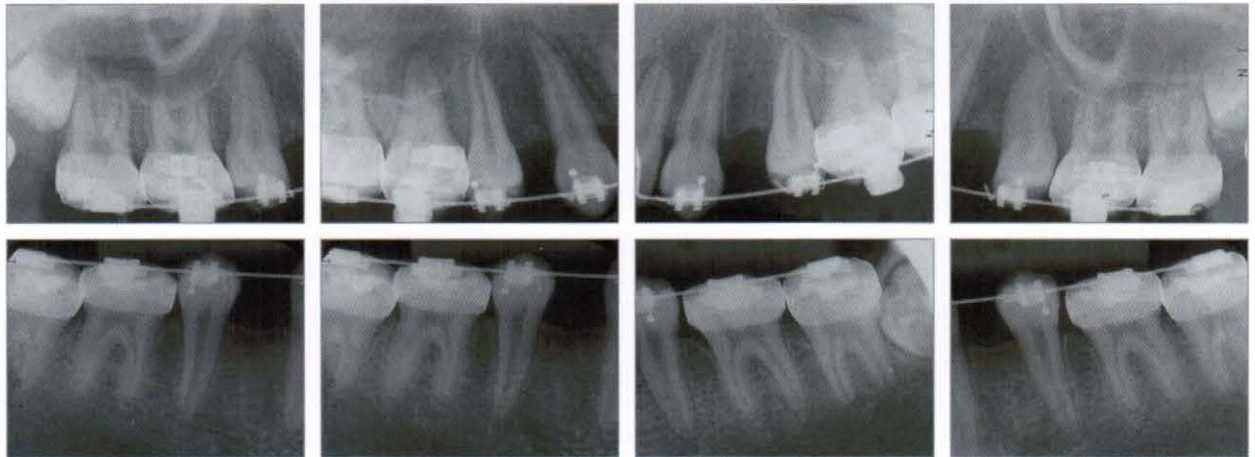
Periapical radiographs (2002, 10,11)
